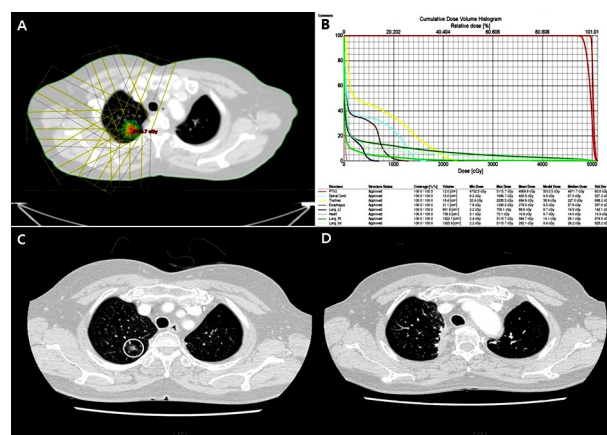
70-year-old female with right upper lung adenocarcinoma. She received daily fractionated radiosurgery using linear accelerator. The dose fractionation schedule was a total 49.5 Gy in 3 fractions. (A) Planning target volume was covered by $\geq 95\%$ isodose curve of prescription dose. (B) Dose-volume histogram. (C) Chest computed tomography (CT) image checked at 1 month before the start of radiosurgery. The lung lesion was located in white circle. (D) Chest CT image checked at 6 month after the completion of radiosurgery. The right upper lung lesion was well ablated.
